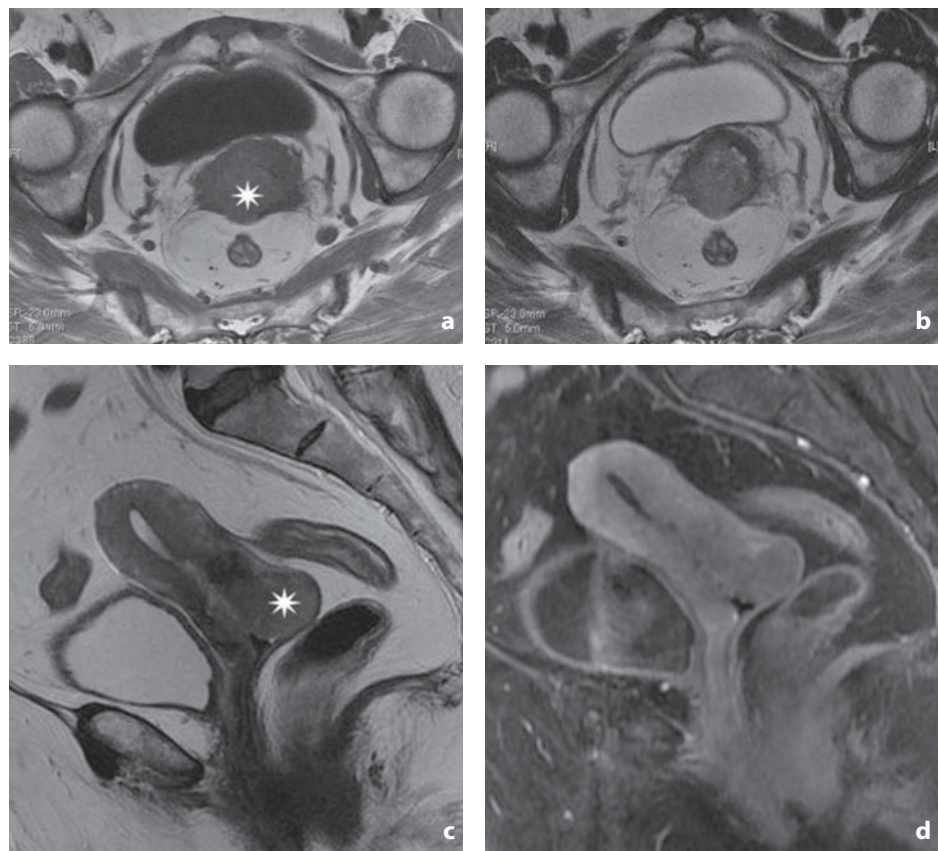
Magnetic resonance. Cervical cancer, stage IIA. Axial T1- (a) and T2-weighted (b) images. Sagittal images weighted in T2 (c) and T1 after contrast medium administration with fat saturation (d). The tumor can be identified invading the posterior vaginal fornix (*asterisk*)
